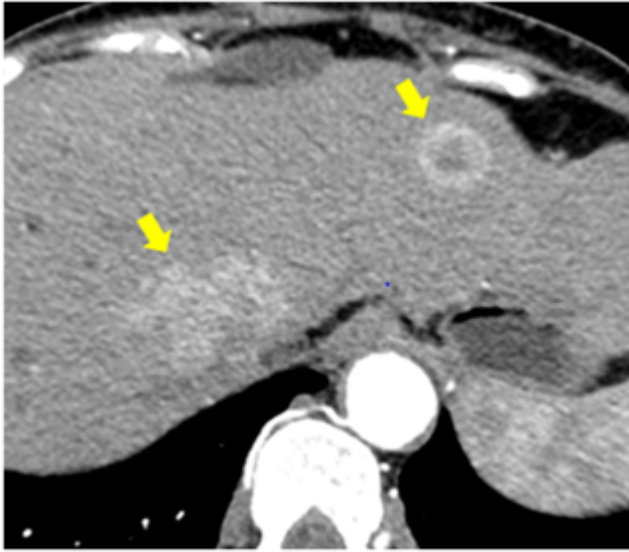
Liver metastasis: Axial sections of CT images showing arterial enhancing masses in segment II and VIII of liver in case of hilar cholangiocarcinoma shown in the figure 6.
